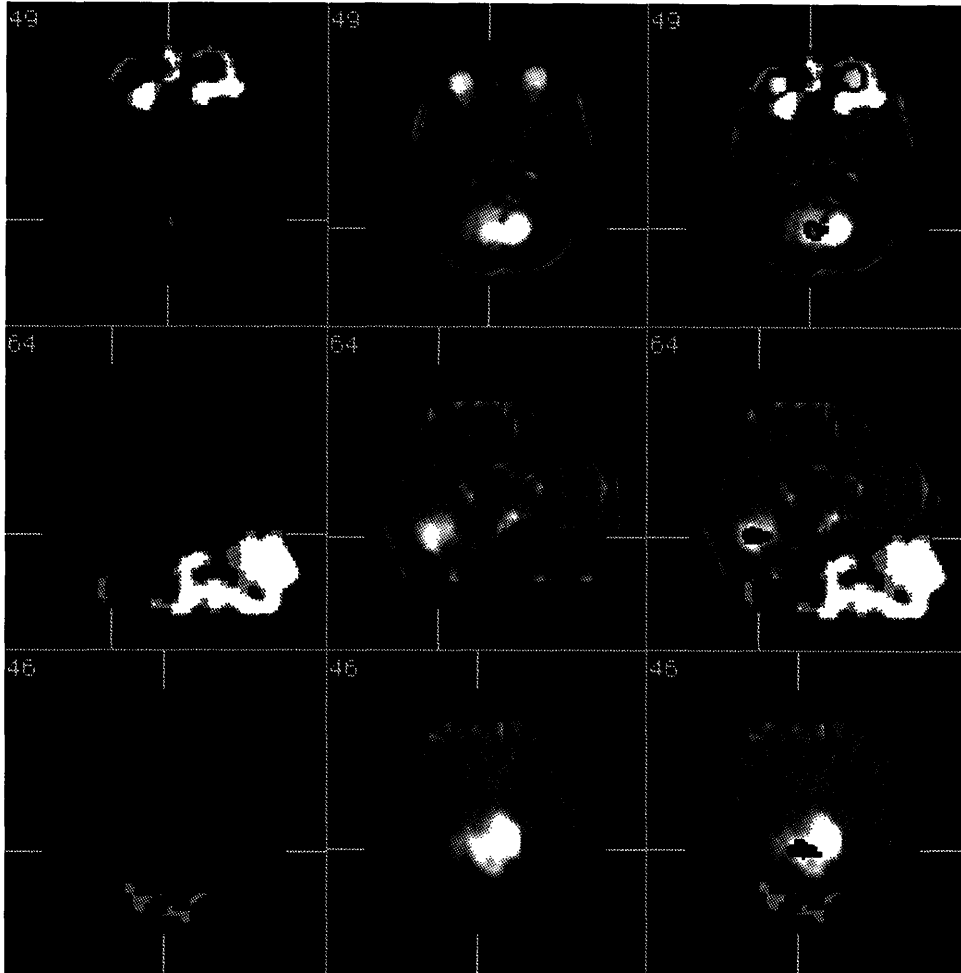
Brain tumor shown on ^{201}Tl -SPECT (left), MRI (center), and a fusion image (right).
